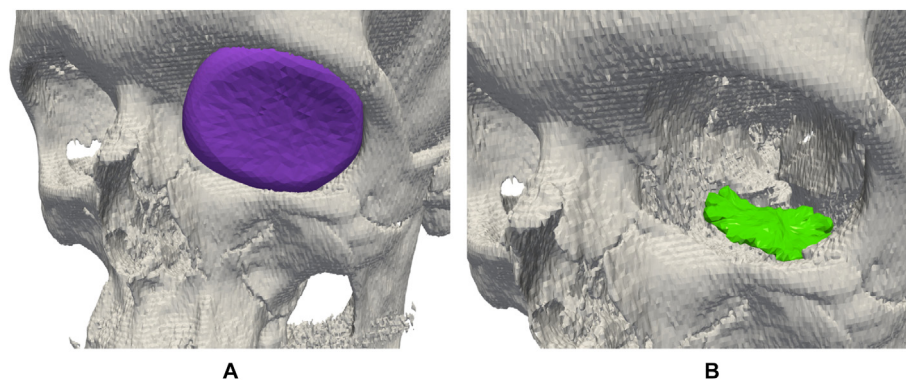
Visualization of orbital fracture component analysis Orbital volume analysis from a preoperative CT image. Segmented orbital volume is shown in Figure 4A in purple and volume expansion caused by orbital floor fracture is shown in Figure 4B in green. Patient is the same as in Figure 1.
